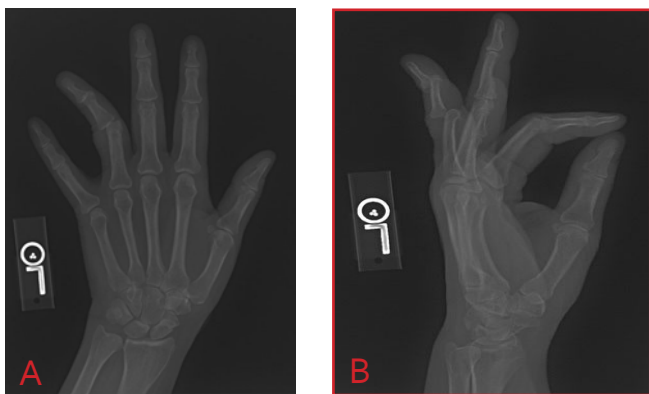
Preoperative radiographs of the left hand, showing simultaneous dislocation of proximal and distal interphalangeal (IP) joints of the left ring finger. (A) Posterior view. (B) Lateral view, with flexion of thumb IP and index distal IP joints.
